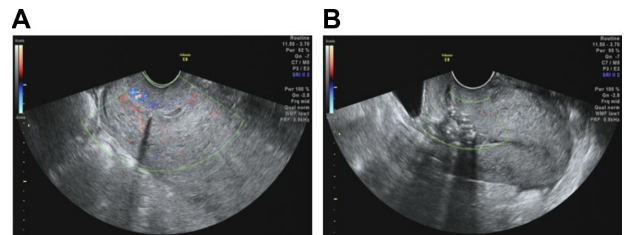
Transvaginal ultrasound image of the uterus 2 days postpartum (A) and 2 months postpartum (B).
